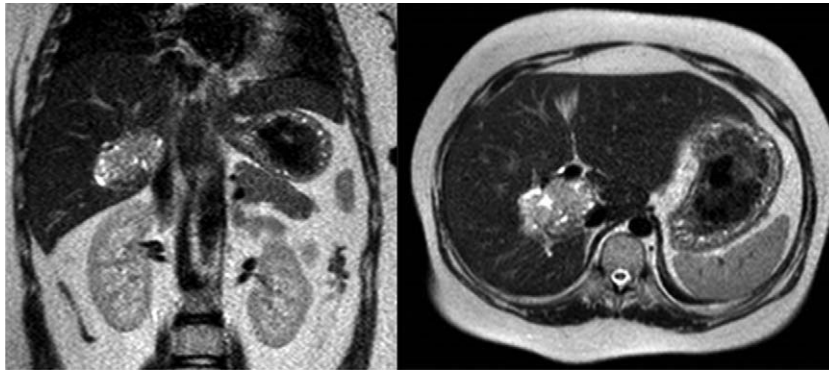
Abdominal MR image of the mass at the time of diagnosis.
